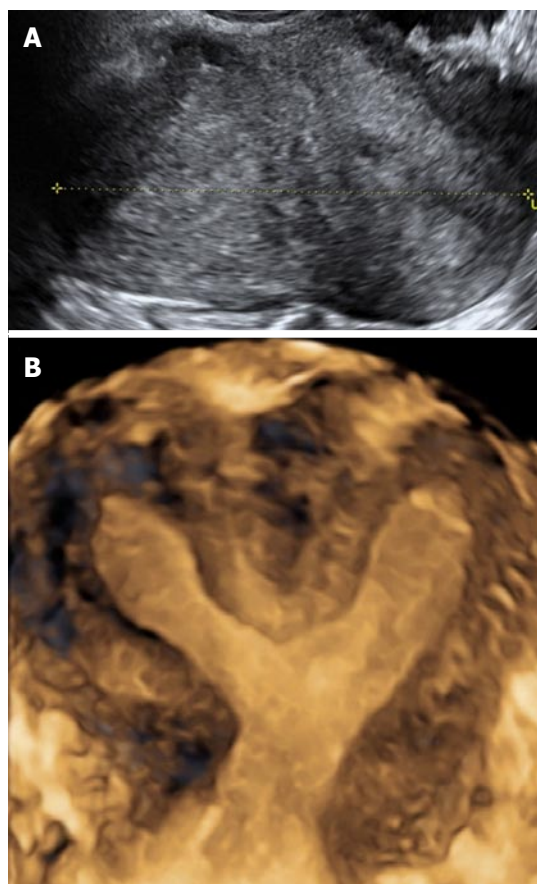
Bicornuate uterus. A: Transverse 2D ultrasound image of a bicornuate uterus showing the presence of 2 endometrial cavities; B: Coronal 3D ultrasound image of a bicornuate uterus showing external cleft ≥ 1 cm and internal indentation ≥ 1.5 cm. Note the presence of fundal soft tissue separating the 2 uterine cavities, which distinguishes it from uterine didelphys. 3D: Three-dimensional; 2D: Two-dimensional.
